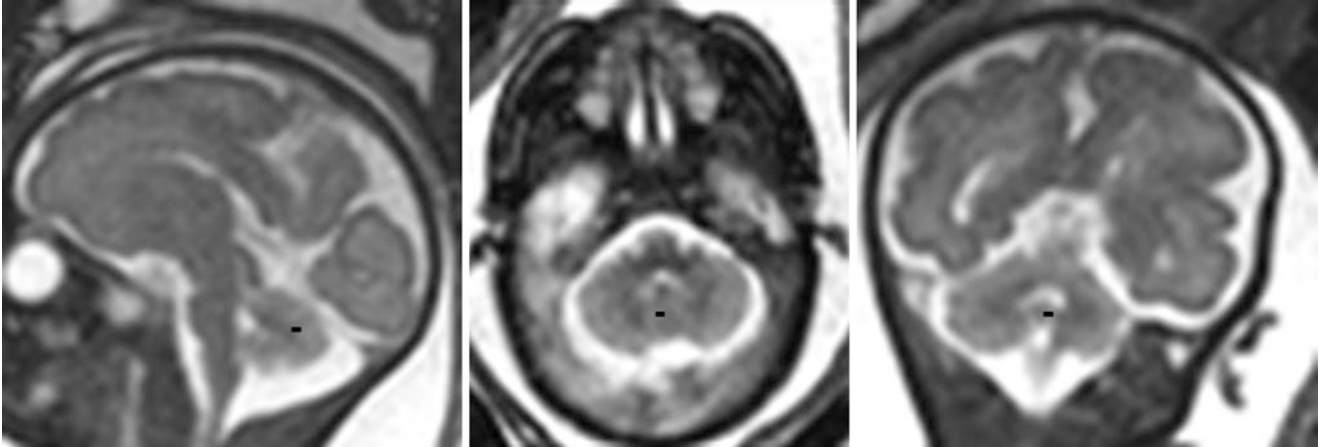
A 29-week-old fetus underwent a fast sagittal T2WI fetal MRI for a possible brain abnormality (negative). On sagittal (*left*), axial (*middle*), and coronal (*right*) ultrafast T2WI, there is mild prominence
